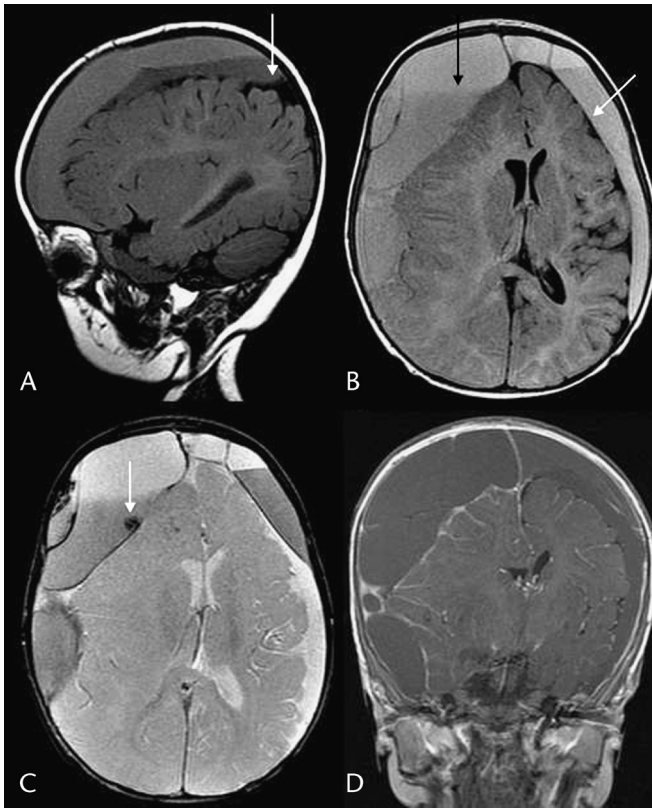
Subdural hematomas in a 5-month-old boy with macrocephaly and seizures. Magnetic resonance imaging demonstrates loculated subdural hematomas with blood products of differing ages. A, Sagittal T1 image shows mixed-intensity subdural collections consistent with acute (or possibly hyperacute) hemorrhage. Note the line separating the collection from the low-intensity subarachnoid space (white arrow). B, Axial FLAIR image shows the separation of the collection from the subarachnoid space (especially over the left convexity, white arrow). The collections have mixed high intensity with fluid-fluid levels (black arrow) and septations present. Cortical veins are not seen crossing the collections. There is mass effect with right to left shift. C, Axial gradient echo (GRE) image shows susceptibility with hypointensities along the septations (white arrow). D, Coronal postgadolinium T1 image shows enhancement of the cortical vessels, and margins of the collections, but no traversing veins.
